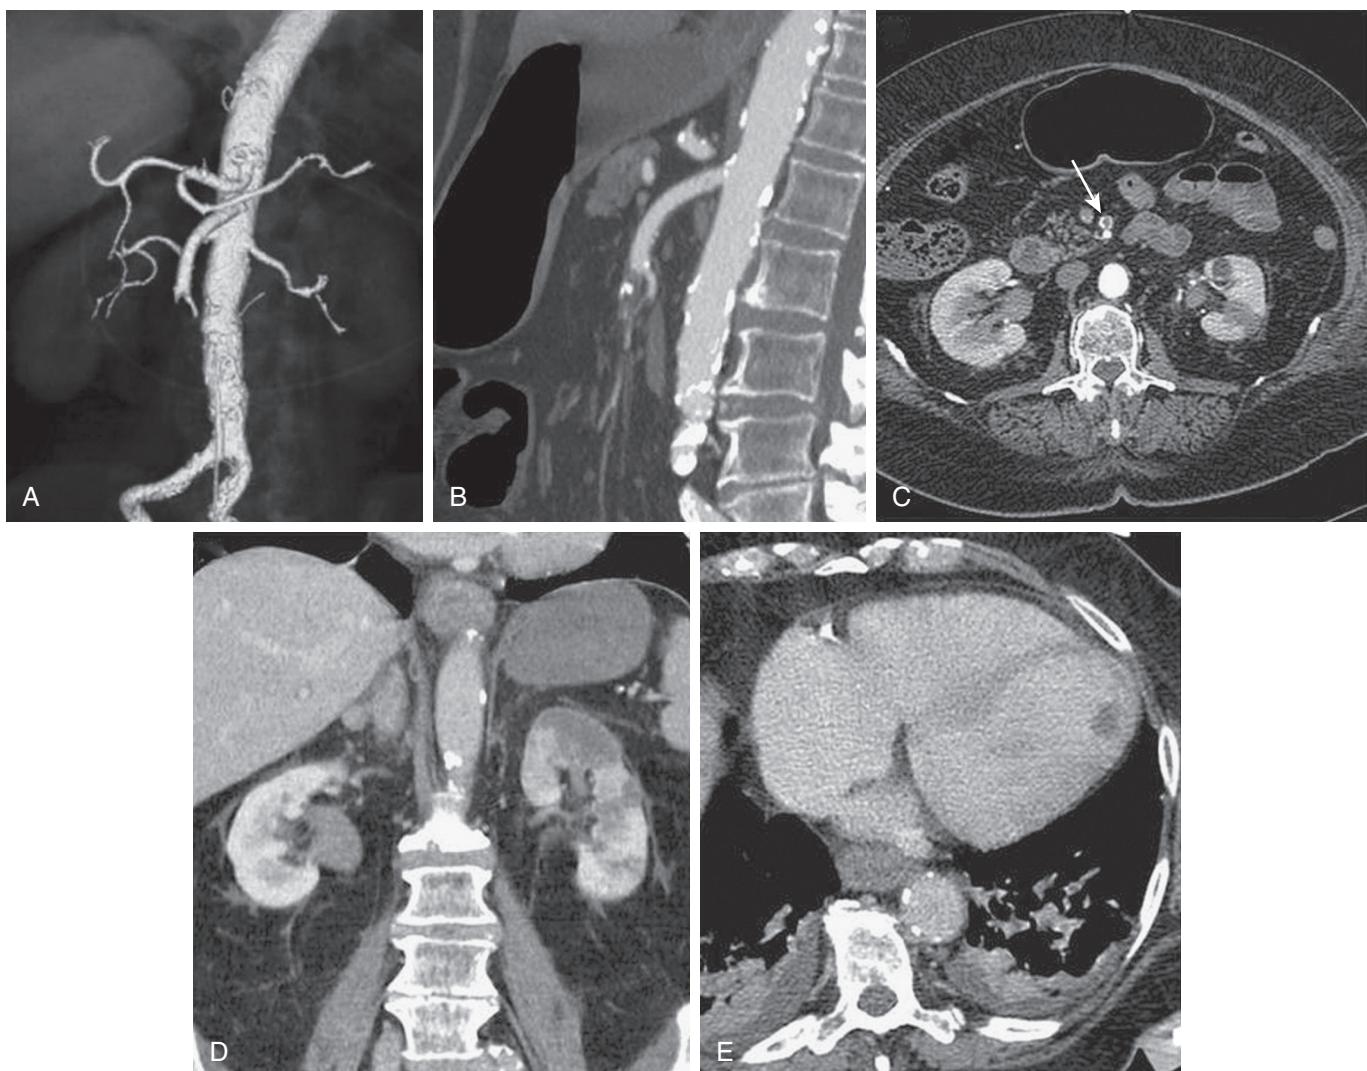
(A) Three-dimensional volume rendering of arterial-phase multidetector computed tomographic angiography (MDCTA) shows an abrupt mid-superior mesenteric artery (SMA) occlusion consistent with embolus. (B) Sagittal multiplanar reformat shows the same occlusion. (C) SMA occlusion seen on an axial CTA slice (arrow). (D) Coronal multiplanar reformat reveals left kidney infarction. (E) Transverse portal venous-phase MDCTA depicts thrombus in the left ventricle as the likely embolic source. (From Aschoff AJ, Stuber G, Becker BW, et al. Evaluation of acute mesenteric ischemia: accuracy of biphasic mesenteric multi-detector CT angiography. *Abdom Imaging*. 2009;34:345–357.)
